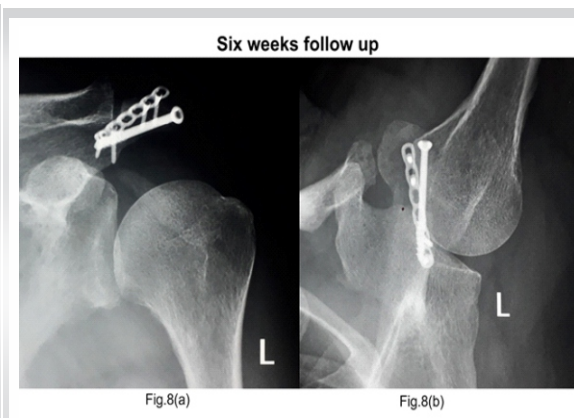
(a and b) Radiographs taken on 6-week follow-up.
